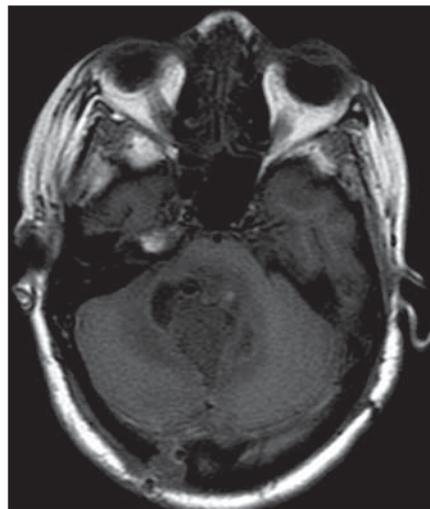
Axial MRI, T1-weighted sequence demonstrating a hypointense mass located in the posterior fossa, obliterating the IV ventricle, with foci of marked hyposignal possibly corresponding to air/gas, also identified in the region adjacent to the craniotomy.
